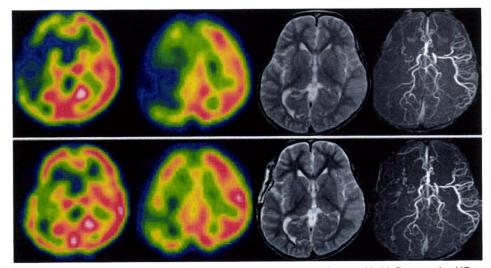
Preoperative (upper) and postoperative (lower) images obtained in a 3-year-old girl. Preoperative MR angiography study showed minimal moyamoya vessels with poor depiction of the MCA in the right hemisphere. Postoperative SPECT study obtained 3 days after surgery revealed improvement of right cortical uptake. On postoperative T2-weighted MR imaging and MR angiography studies obtained 1 week after surgery, the right STA-MCA bypass and the branch of the right MCA were well visualized, and no significant postoperative lesion was seen.
